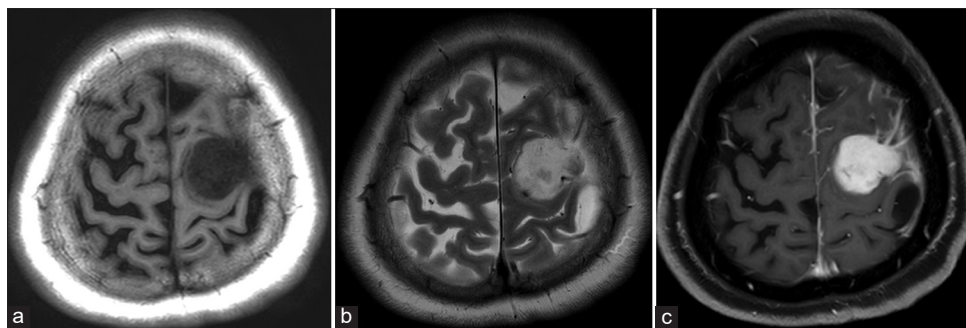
Magnetic resonance imaging (MRI) on admission (a-c). An extra-axial tumor on the left frontal lobe is hypointense on T1-weighted image (a) and hyperintense without peritumoral edema on T2-weighted image (b). Gadolinium-enhanced T1-weighted image shows a homogeneously enhanced tumor with leptomeningeal enhancement around the tumor.
